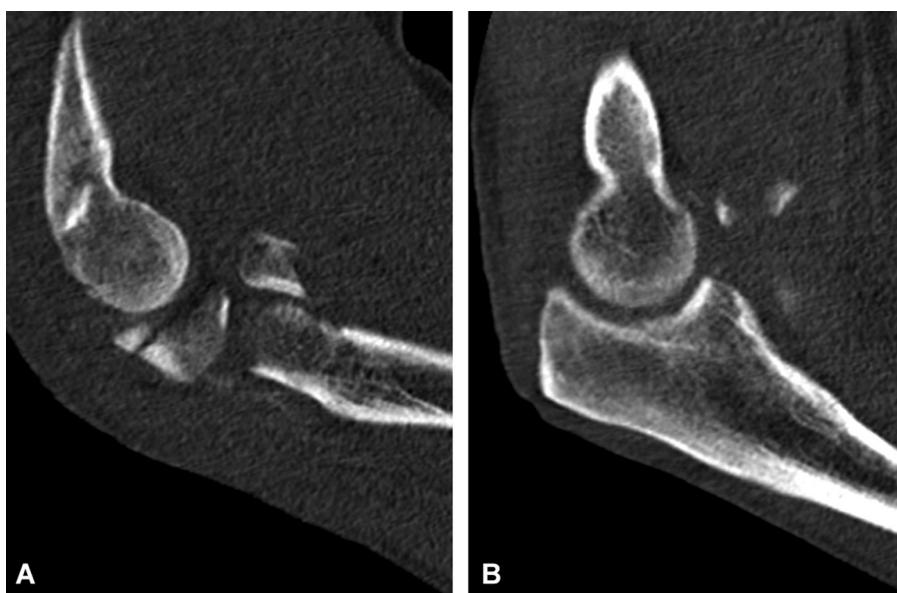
CT scan following closed reduction. A: Sagittal view through the radiocapitellar joint revealing a comminuted, displaced radial head fracture. B: sagittal view through the ulnohumeral joint showing a coronoid tip fracture, type I according to Regan and Morley [7].
